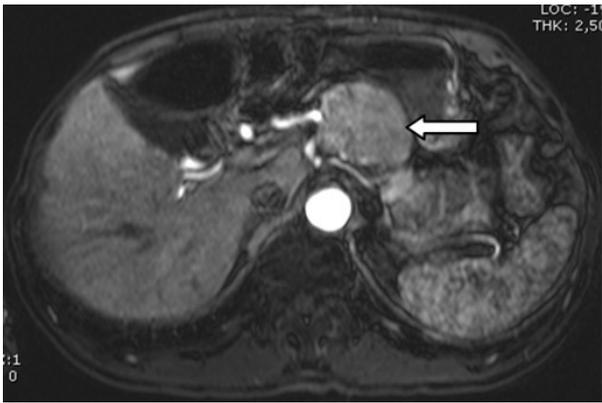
Magnetic resonance imaging showed a 5.5x4.5 cm mass arising from the pancreatic body (white arrow).
